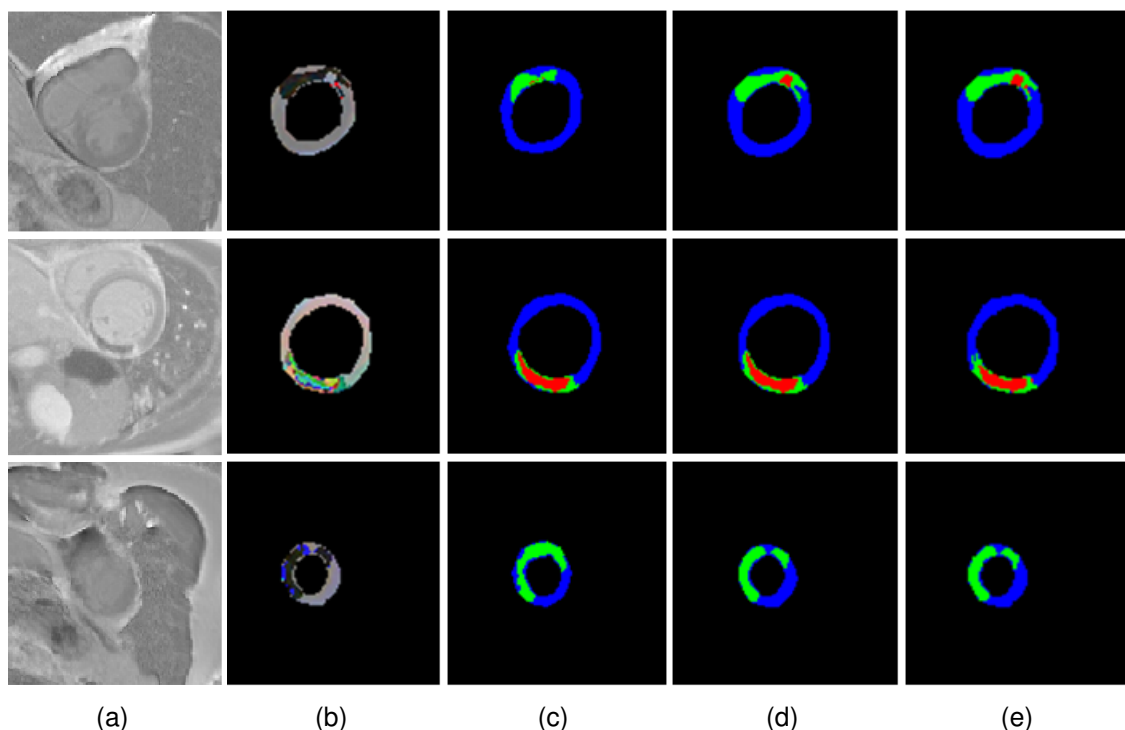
Representative three slices from three test input cases and relative masks. From left to right : (a) Original LGE-MRI , (b) 2.5D Input images, (c) First intra manual segmentation, (d) Second intra manual segmentation, and (e) 2.5D SegU-Net generated-result. (MYO (blue), MI (green), and MVO (red)).
